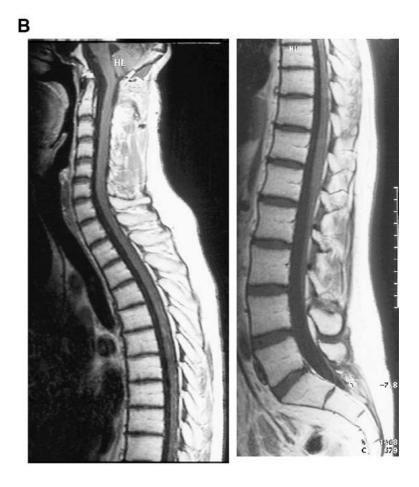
Sagittal T1-weighted magnetic resonance (MR) images with gadolinium-diethylenetriamine-penta-acetic acid. (A) Preoperative MR image revealing diffuse leptomeningeal dissemination to the whole spinal cord. (B) MR images 18 months after the combined therapy revealing complete disappearance of the dissemination
